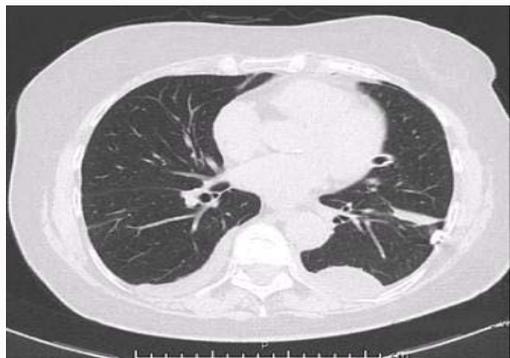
Computed Tomography (CT) image showing bilateral pleural effusion and left pleural thickening.
